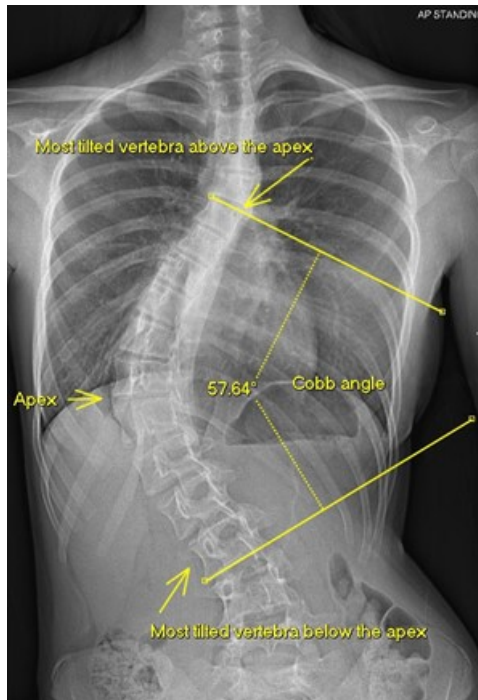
X-ray showing dorsolumbar scoliosis and demonstration of calculation of Cobb angle.
